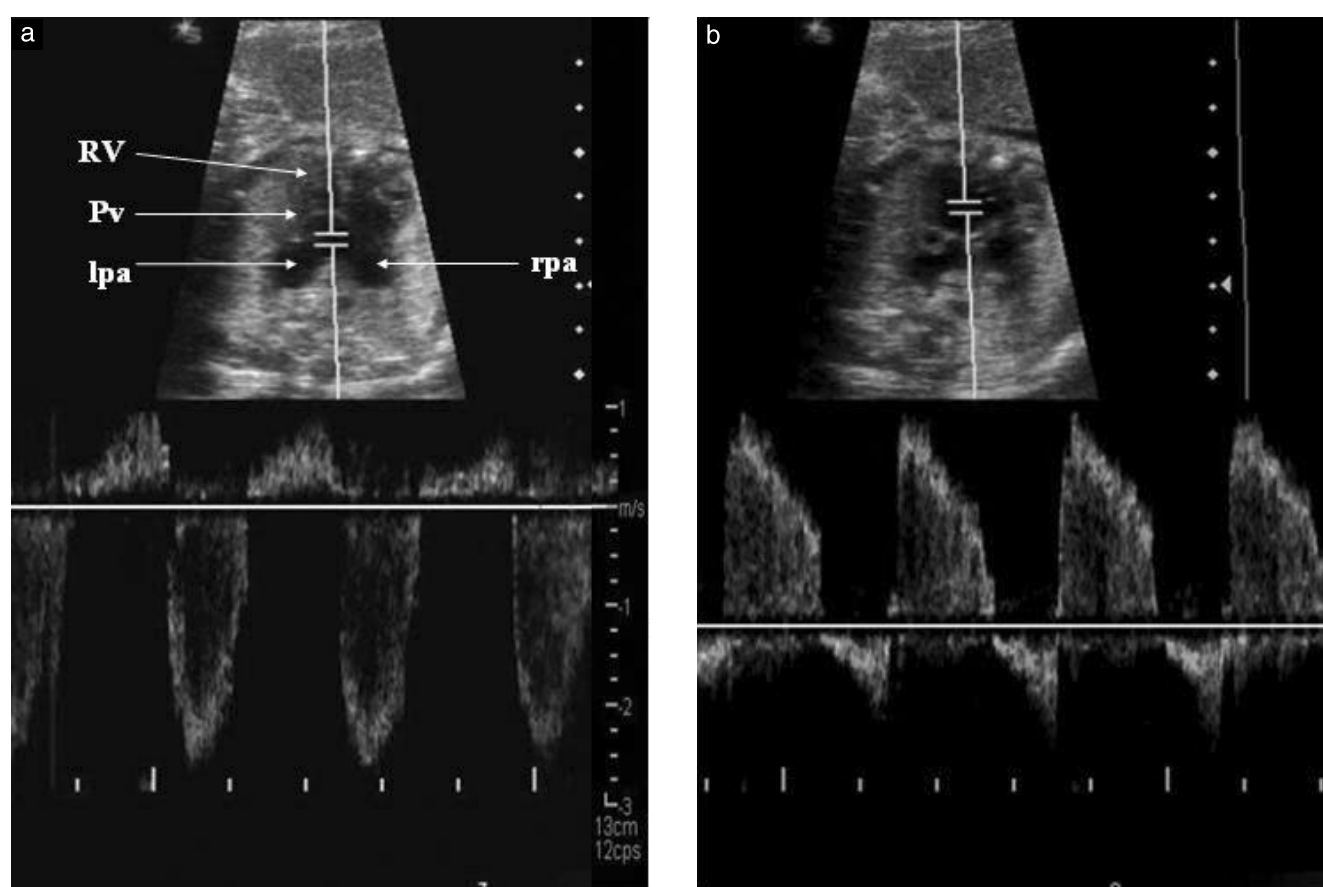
Pulsed Doppler recording showing antegrade and retrograde flow in (a) the pulmonary trunk and (b) the right ventricle. lpa, left pulmonary artery; Pv, pulmonary valve; rpa, right pulmonary artery; RV, right ventricle.
